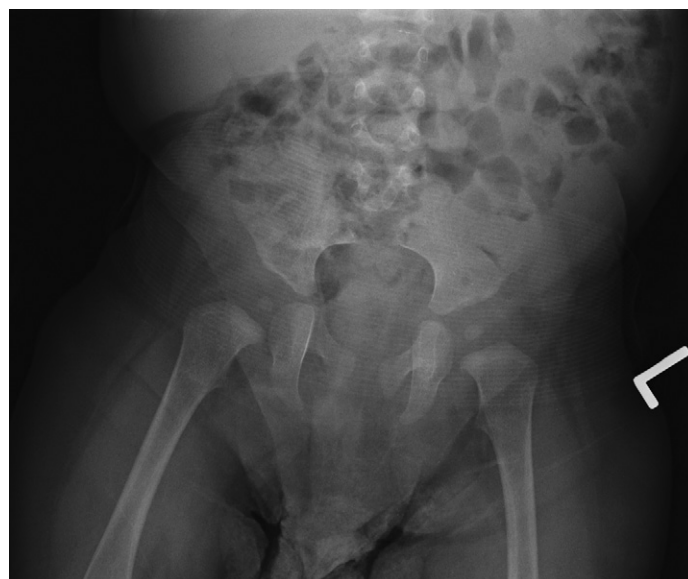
Sacral agenesis. Plain radiograph shows complete agenesis of the sacrum. (Image courtesy of Vikram Dogra, M.D.)
